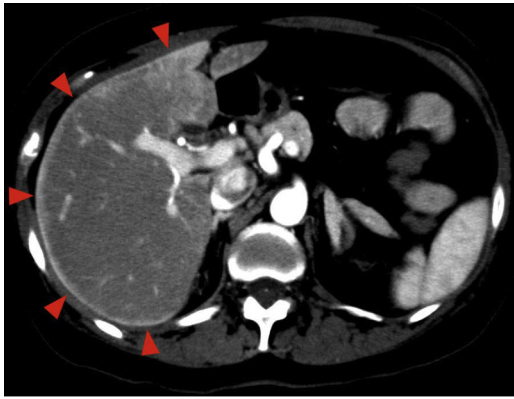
Contrast-enhanced computed tomography of the abdomen demonstrated linear enhancement of the hepatic capsule (arrowheads).
